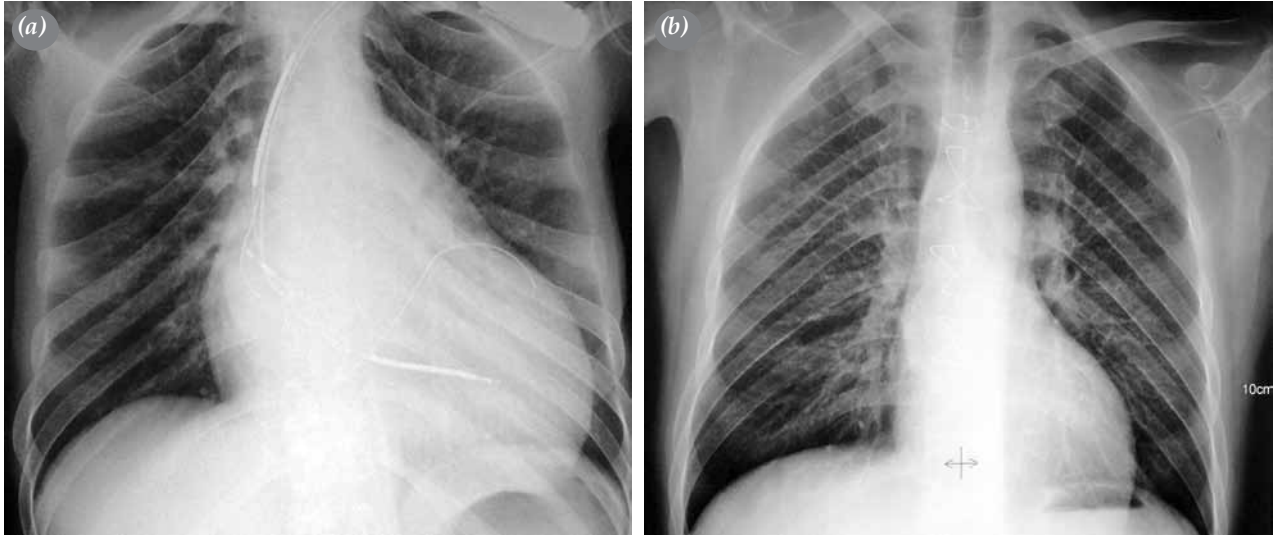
(a) Chest roentgenogram shows the cardiac enlargement with a normal silhouette of the ascending aorta and permanent defibrillator preoperatively. (b) Postoperative chest film shows a normal sized heart with ascending aorta.
